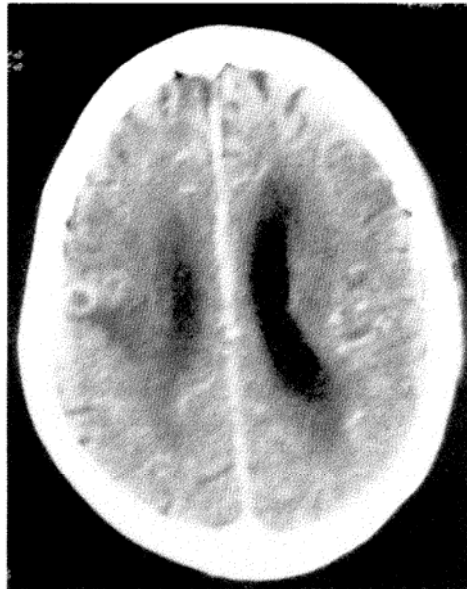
Ring enhancing lesion in CT brain.
